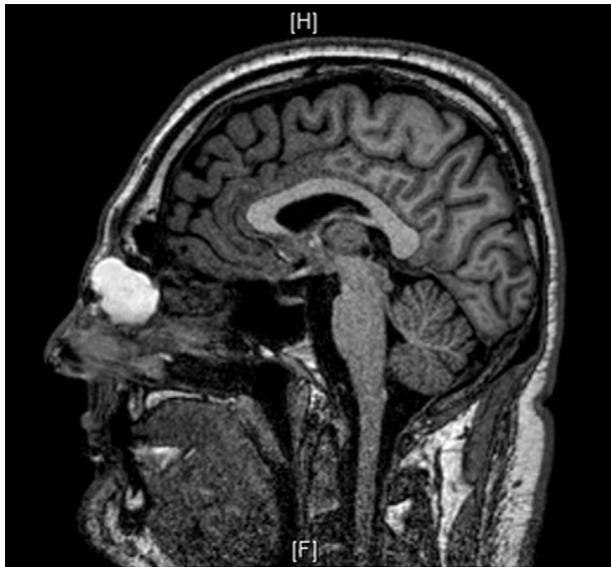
Sagittal T1 MRI without contrast through the brain showing the nasal mucocoele.
